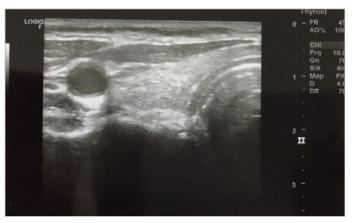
Thyroid ultrasonography of our patient showing homogeneous parenchyma with normal echogenicity.
